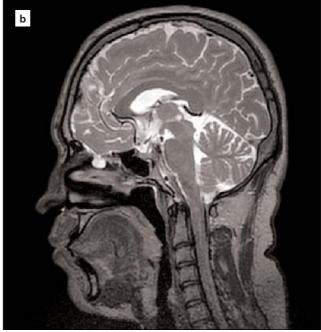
(a) Endoscopic view of nasal polypoid lesion (meningoencephalocele sac) between middle turbinate and nasal septum. M: middle turbinate, S: superior turbinate, NS: nasal septum. *Meningoencephalocele sac. (b) Meningoencephalocele sac was shown in FIESTA T2-weighted MR sagittal section.
